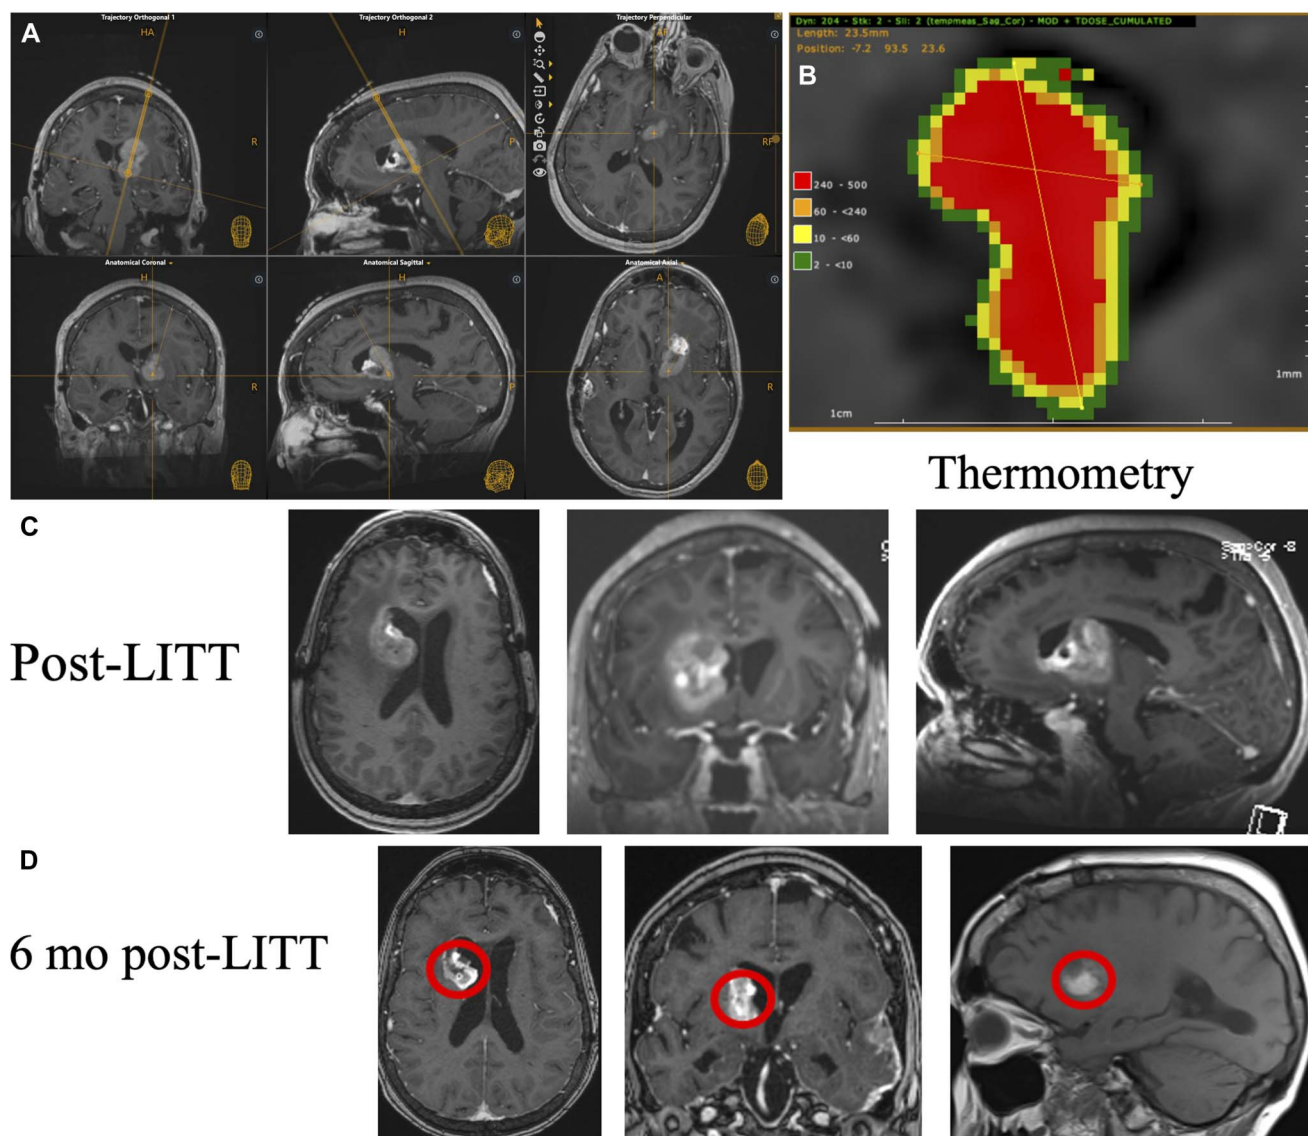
A 67-year-old woman with a history of stage IV melanoma who was found to have progressive growth of a right thalamic lesion 10 months after radiosurgery. A, Multiplanar postcontrast MRI images (T1 with gadolinium) demonstrating stereotactic localization and right frontal-insular approach to the target lesion. From right to left, top row: axial, sagittal, sagittal images; the top row shows the planned trajectory superimposed onto the anatomic images (orange). B, Intraoperative thermometry with the 15-mm diffuser probe. Two ablations were performed in 2 serial depths. The ablation cavities measured 9.5 × 12.5 and 15 × 11.5 mm, encompassing 100% of the target lesion. See Figure 1D for thermometric assessment. C, Immediate, postoperative axial, coronal, and sagittal MRI images (T1 with gadolinium) demonstrating expected ablation cavity. D, Six months postoperative postcontrast axial, coronal, and sagittal MR images (T1 with gadolinium). LITT, laser interstitial thermal therapy.
